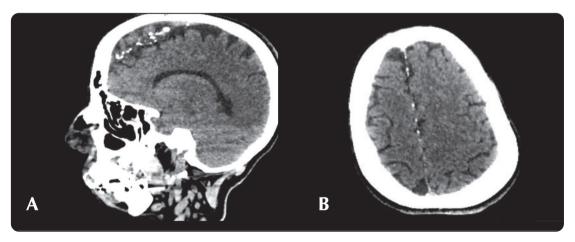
ACT sagittal view showing falx cerebri calcification. (B) CT axial section showing falx cerebri calcification
